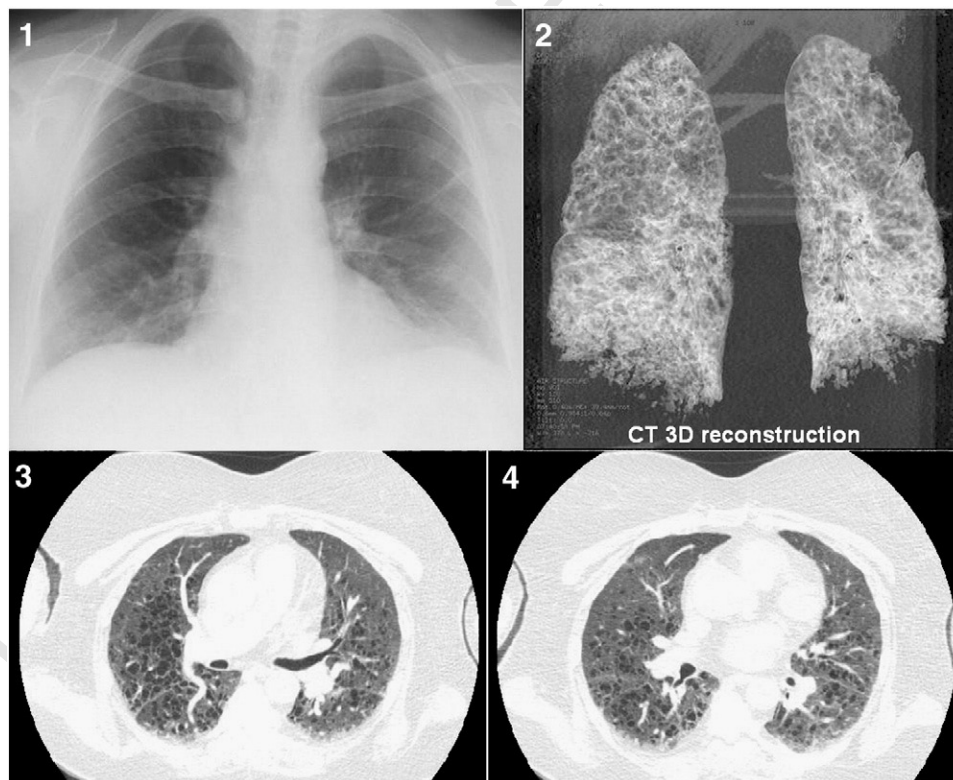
Different radiological imaging modalities of the chest in a patient with multisystemic Langerhans cell histiocytosis with pulmonary involvement (female, born 1955). The patient presenting with fevers and dyspnea was admitted to hospital with suspected pneumonia in July 2010. There were no abnormalities seen on conventional radiography (1), in contrast to HRCT imaging (3 and 4) showing apart from hypostatic pneumonia also diffuse small cysts (4–15 mm in size) in both lung fields resembling emphysema, which was visualized using 3D reconstruction (2). Cystic lung disease, complicated by bacterial infection, was an accidental finding in this patient. However, retrospective analysis of the SUVmaxPULMO/SUVmaxHEPAR index in preceding four PET examinations (2004–2010) shows a high probability of a previous history of PLCH (Table 2).
